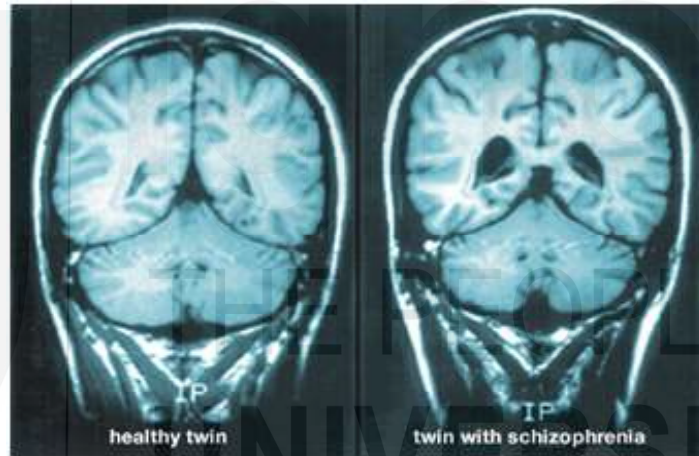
MRI scans of twins: a healthy twin and one with schizophrenia showing enlarged brain ventricles in the sibling with schizophrenia
